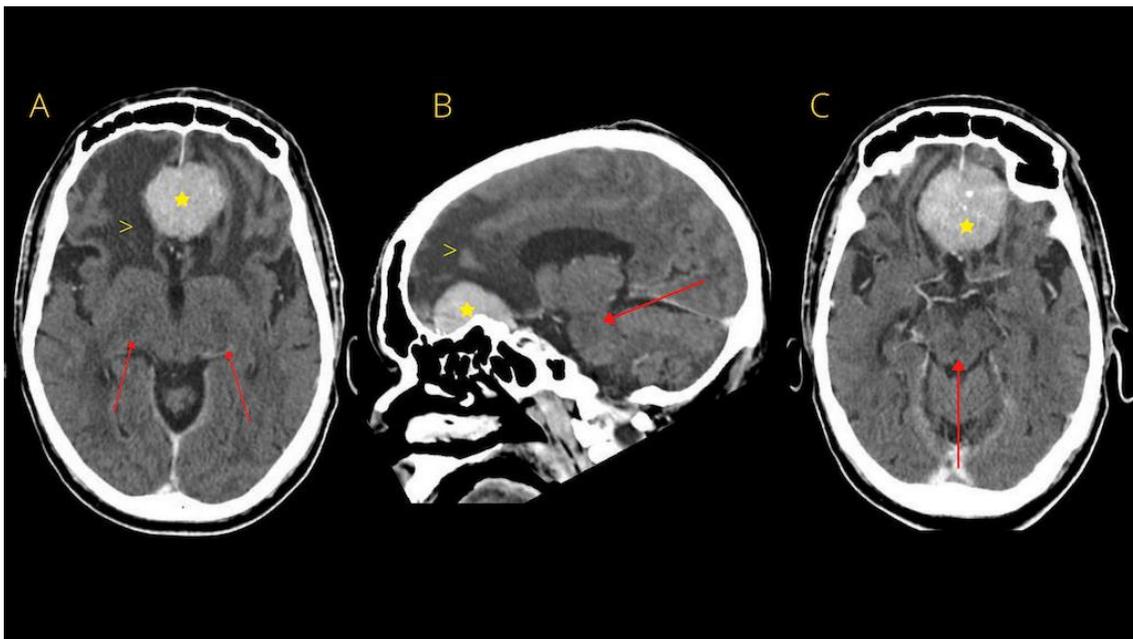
Noncontrast brain CT-scan showing a large enhancing bifrontal mass (yellow star) with surrounding vasogenic edema (yellow arrowhead) (2A). The lesion affects the base of the skull (2B). Contrast enhanced CT after seven days of systemic corticosteroids (2C): there is persistence of large enhancing bifrontal mass with internal calcification and marked reduction of brain edema. All images show centrally located region of low attenuation within the pons (red arrows) compatible with central pontine myelinolysis.
